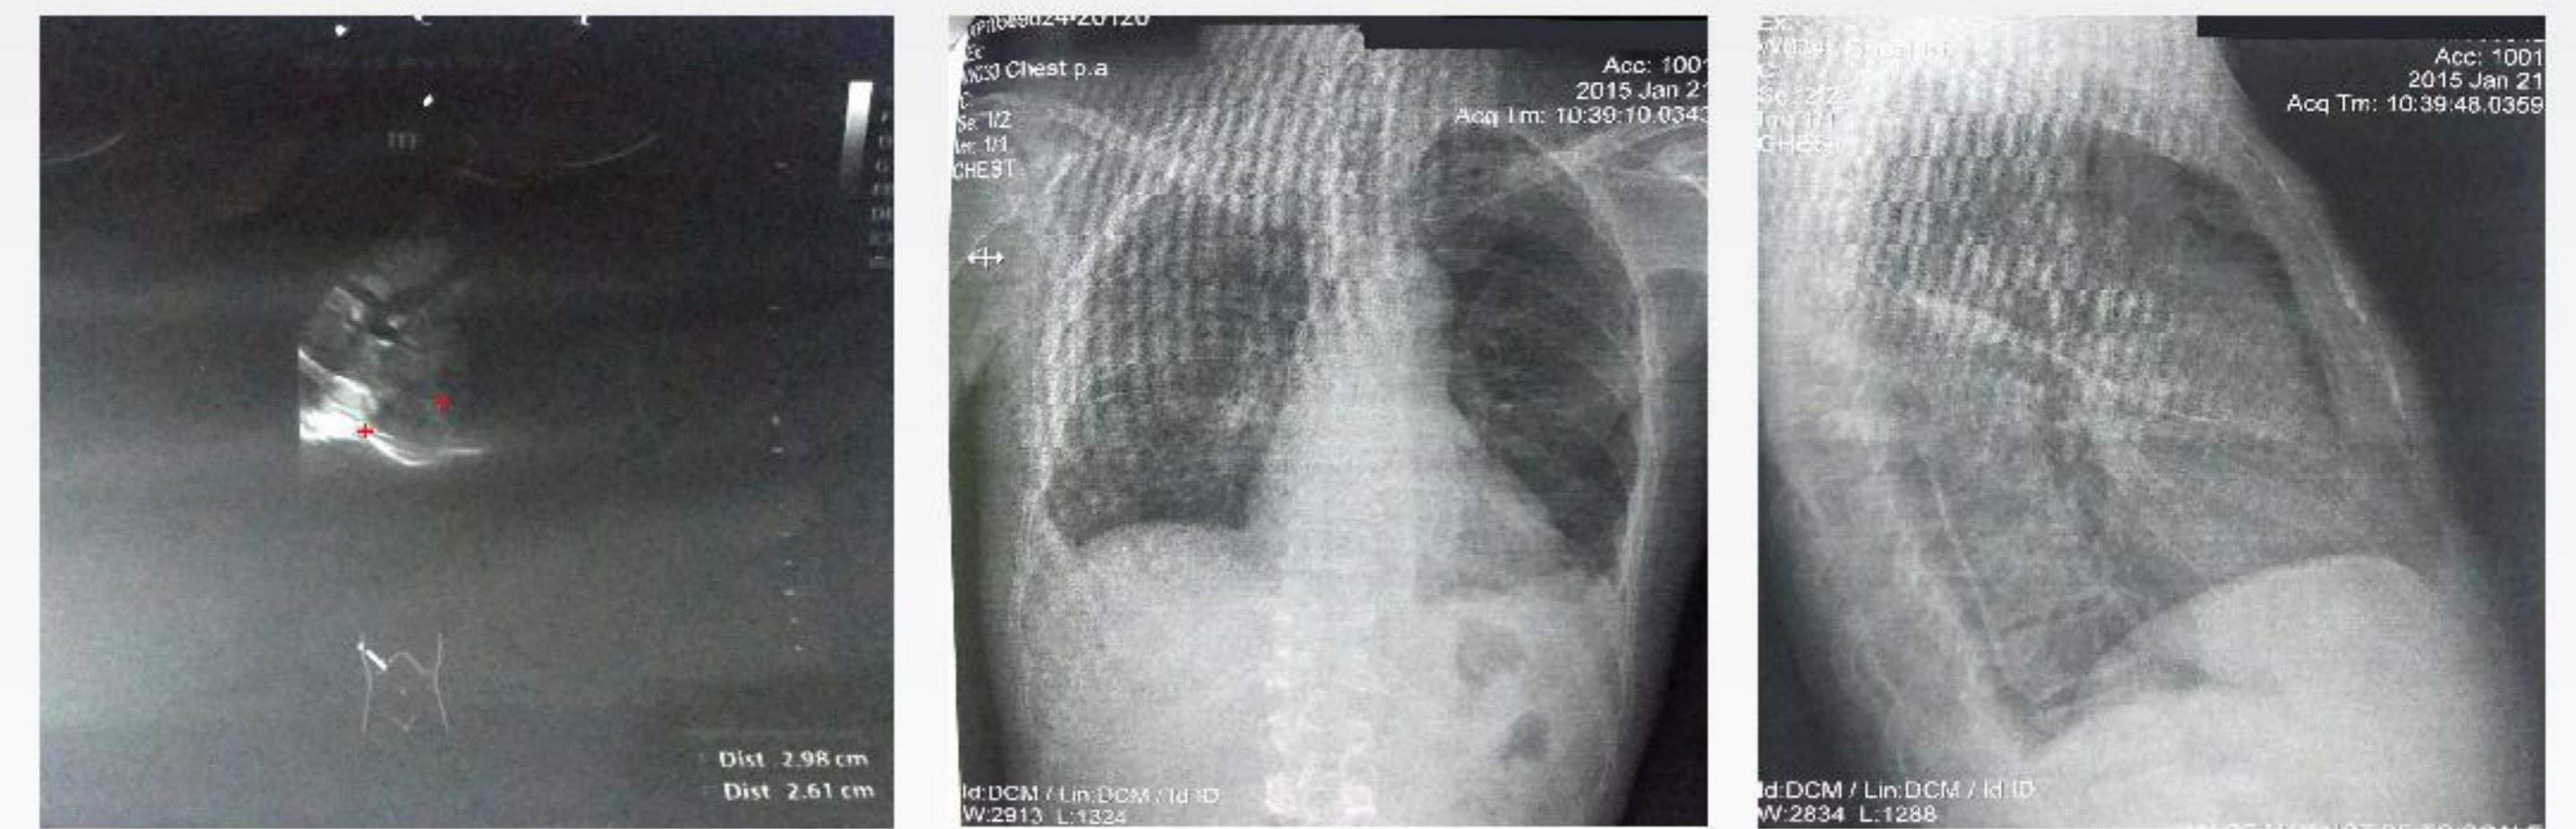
Left adrenal ultrasound
